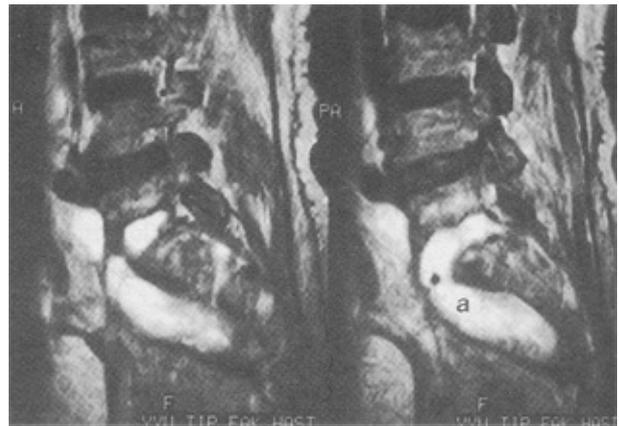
Lumbosacral magnetic resonance image scan showed abscess between L5-S1 vertebrae in sagittal plane (a: Prevertebral abscess).
